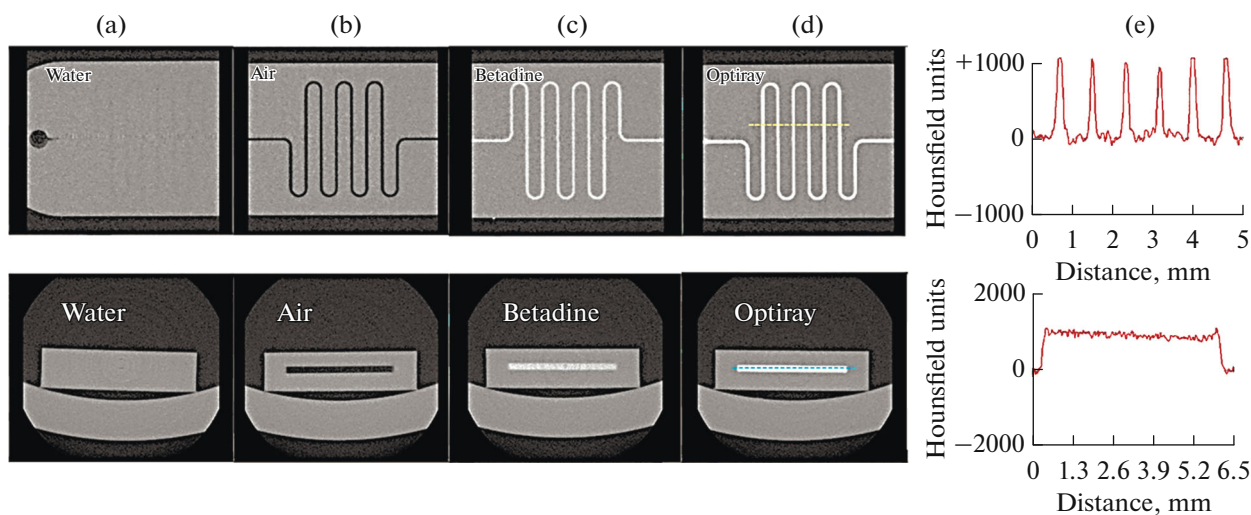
2D visualization in the top and side views for a microfluidic chip with a cross section of channels equal to $124\ \mu\text{m}$ filled with: (a) distilled water, (b) air, (c) betadine, and (d) Optiray; (e) distribution of the X-ray density of a substance in a microfluidic chip filled with Optiray-based contrast agent for a series of cross sections (along the line in the top part of Fig. 2d) and the longitudinal section of the channel (along the line in the bottom part of Fig. 2d).
